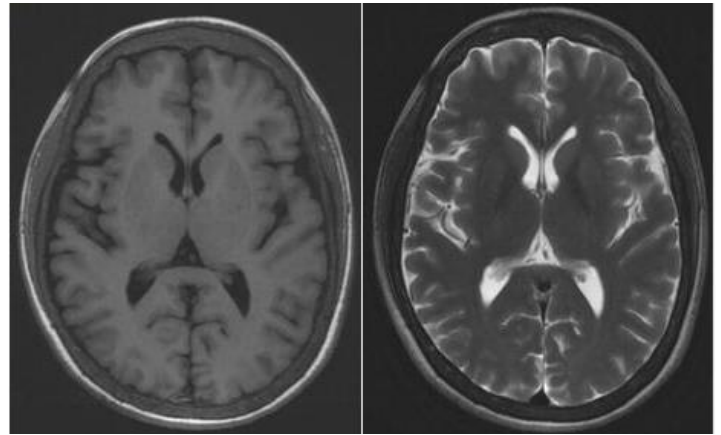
T1WI and T2WI axial MR images showed thickening of cranial diploe.
